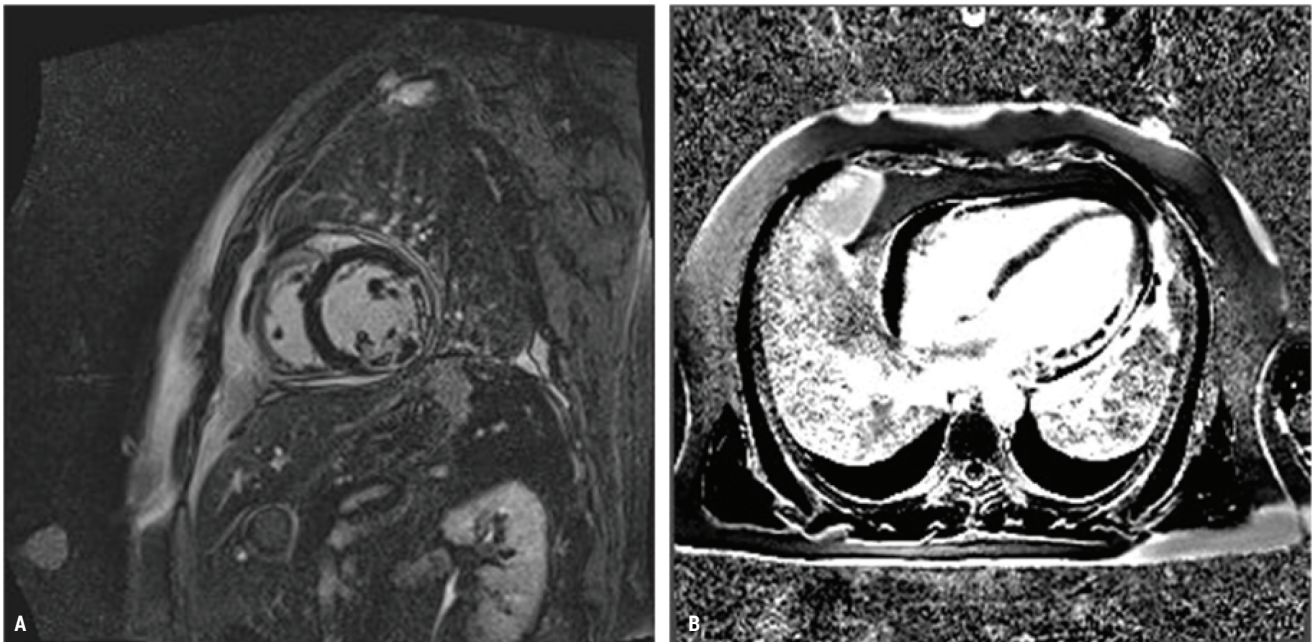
Cardiac MRI short axis view (A) and four chamber view (B) with transmural fibrosis and an area of microvascular obstruction in the lateral and inferolateral wall of the left ventricle.
